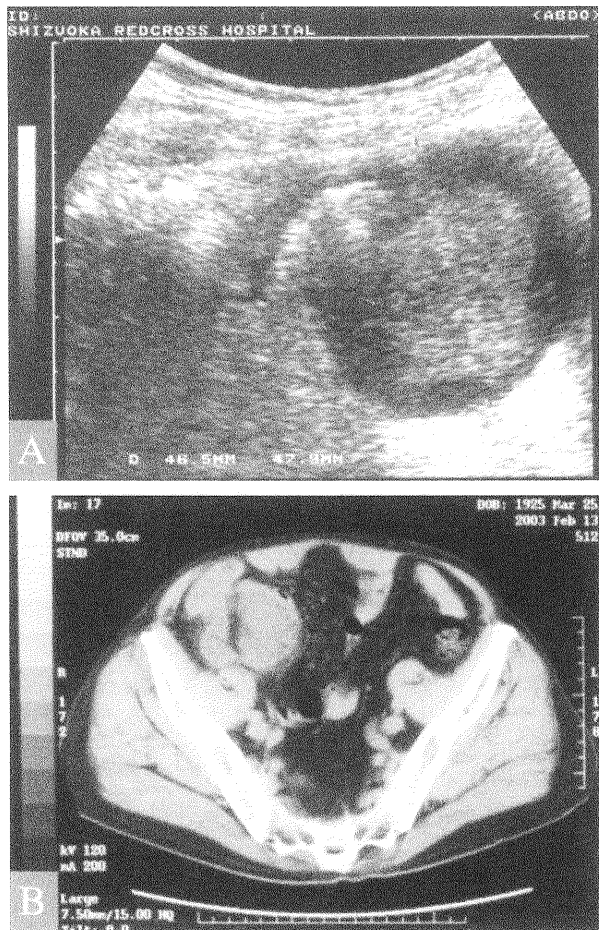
A; Ultrasonography reveals a non-homogenous hypoechoic mass with a peripheral hypoechoic band. B; Computed tomography shows a nonhomogenous soft tissue mass in the right lower quadrant of the abdomen and associated anteromedial displacement of the terminal ileum.
